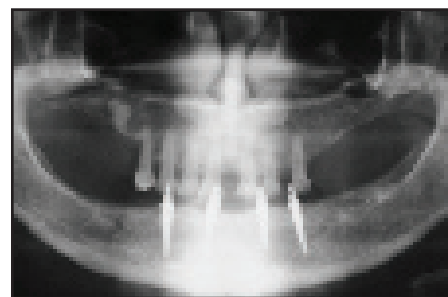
Panoramic radiograph at 24 months
